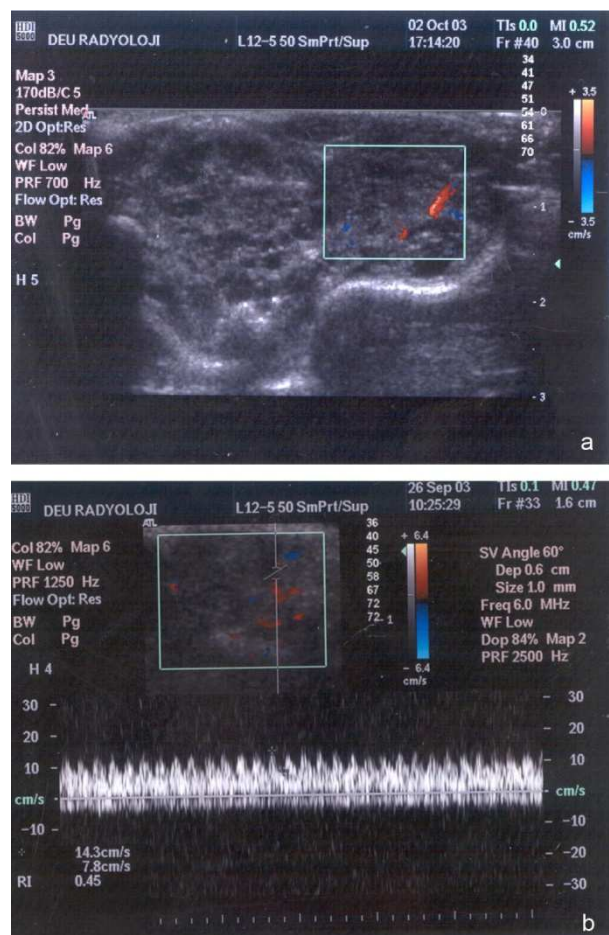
A. Longitudinal abdominal Doppler US of a *meriones unguiculatus* infected with peritoneal implantation of Em, showing the vascular heterogeneous mass lesion occupying the entire abdominal cavity with vascular color-coding areas. B: Spectral analysis of some of the vascular structures showing dominant arterial flow with low peripheral resistance (RI:0.45).
